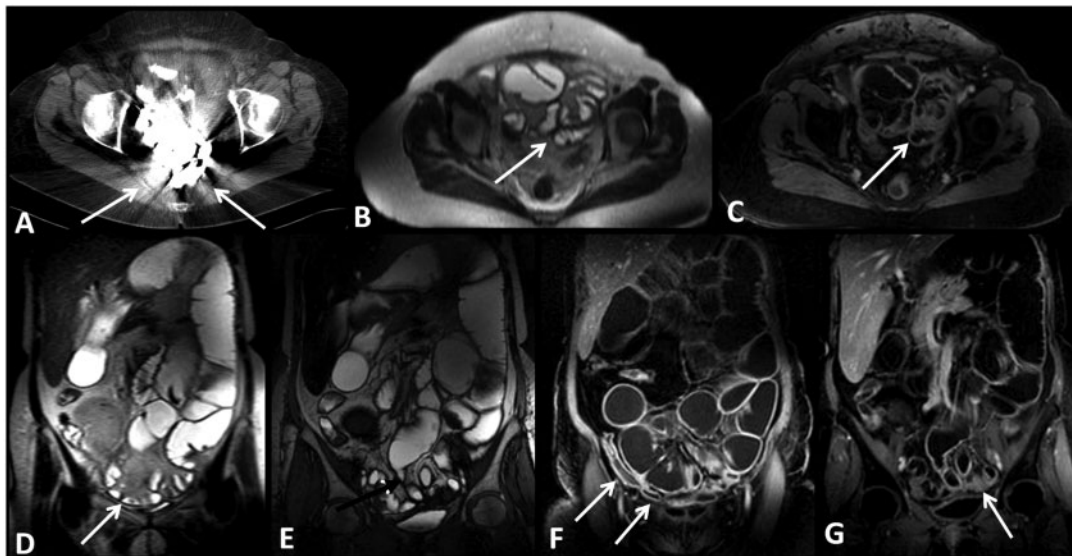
Case 2. Axial CT image demonstrates significant streak artifacts secondary to barium residues from previous lower gastrointestinal series (arrows, A). Axial HASTE image demonstrates wall thickening, luminal narrowing of a long segment of distal ileum (arrow, B). Axial post-contrast T1W image demonstrates contrast material enhancement in the bowel walls of narrowed distal ileum (arrow, C). Coronal HASTE image demonstrates dilatation of the jejunum and luminal narrowing in the distal ileum (arrow, D). Coronal TruFISP image demonstrates the transition zone (black arrow, E). Coronal post-contrast fat-saturated T1W MR images demonstrate contrast material enhanced bowel walls and luminal narrowing (arrows) in the distal ileum (F,G).
